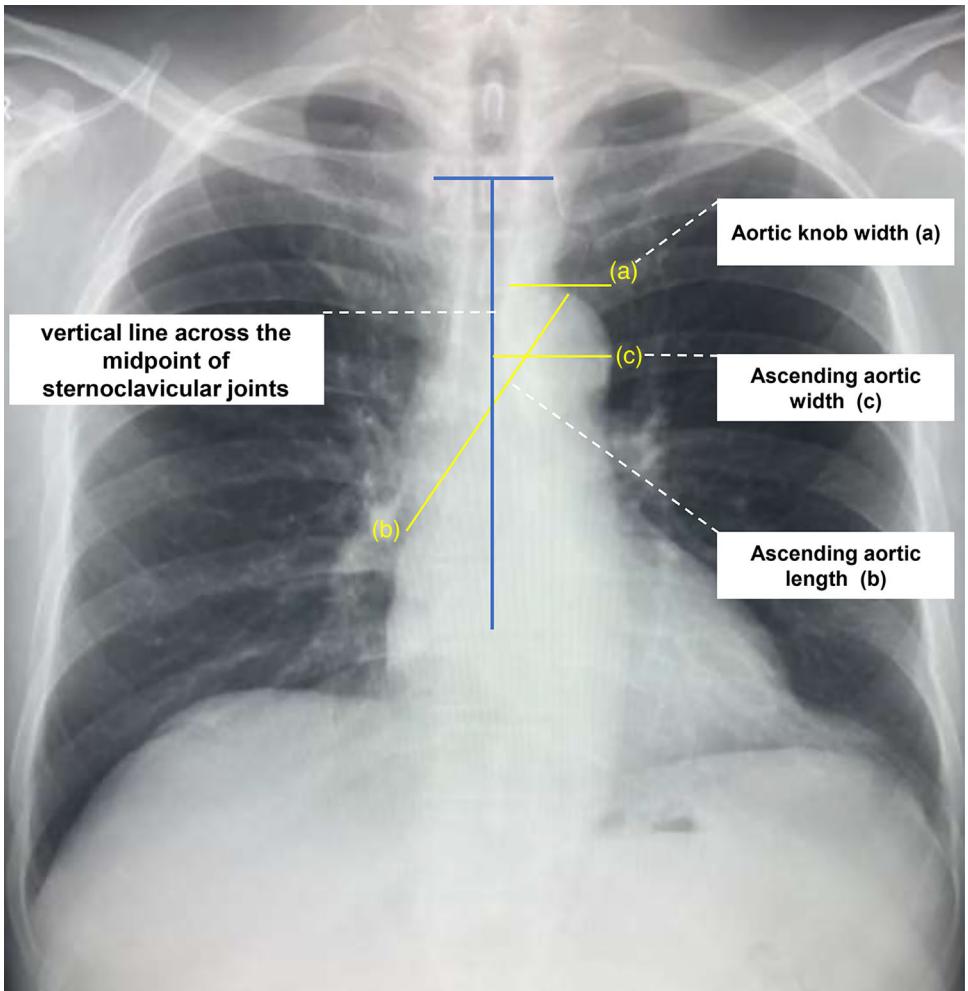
The measurement of thoracic aortic parameters in chest x-ray. (a) Aortic knob width (AKW) was measured as the distance from the right margin of the aortic arch to the left margin of that. (b) Ascending aortic length (AAL) was measured as the distance from the indentation at the right margin of the heart to the apex of the aorta. (c) Ascending aortic width (AAW) was measured as the distance from the leftmost margin of the aorta to the vertical line across the midpoint of the sternoclavicular joints.
